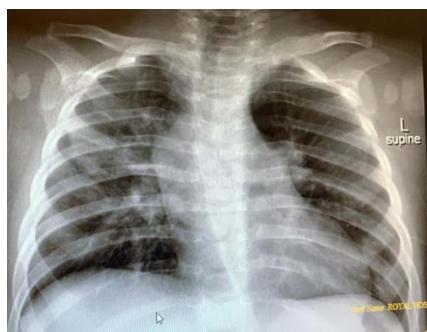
Chest x-ray of the child
